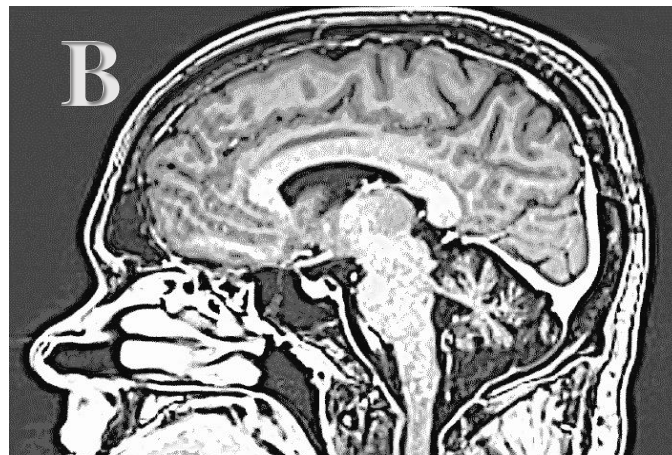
(b): Brain MRI, sagittal T1 post-gadolinium sequence, showing volume loss of the overall posterior fossa, especially the cerebellar vermis, associated with ex vacuo ectasia at the level of the fourth ventricle.
